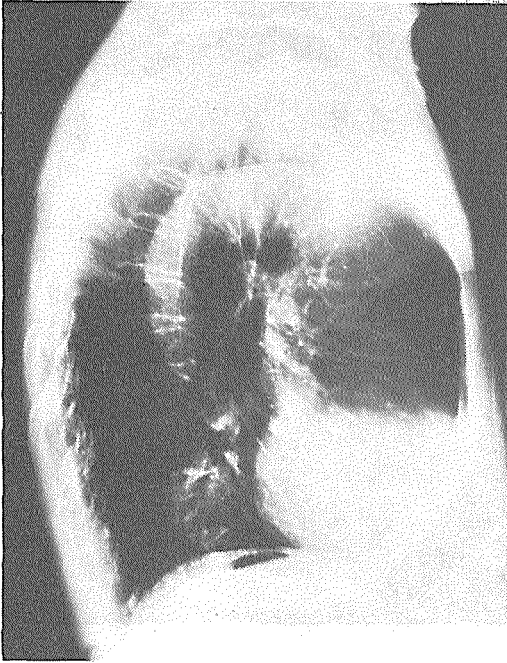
Lateral lung X-ray in January 1991.
